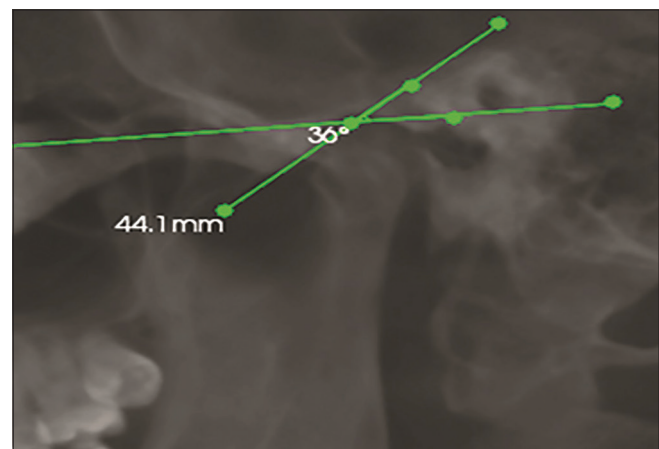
Cone-beam computed tomography interpretation of a subject
